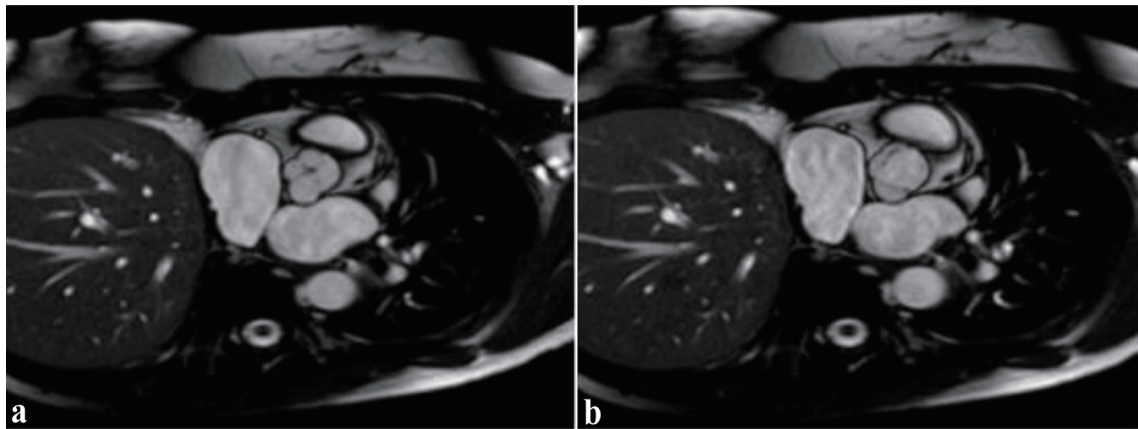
Cardiac magnetic resonance imaging in short-axis view demonstrating quadricuspid aortic valve morphology. (a) Diastolic phase: incomplete cusp coaptation with central aortic regurgitation orifice, consistent with moderate aortic regurgitation. (b) Systolic phase: the aortic valve leaflets are fully open, visualizing four distinct cusps.
